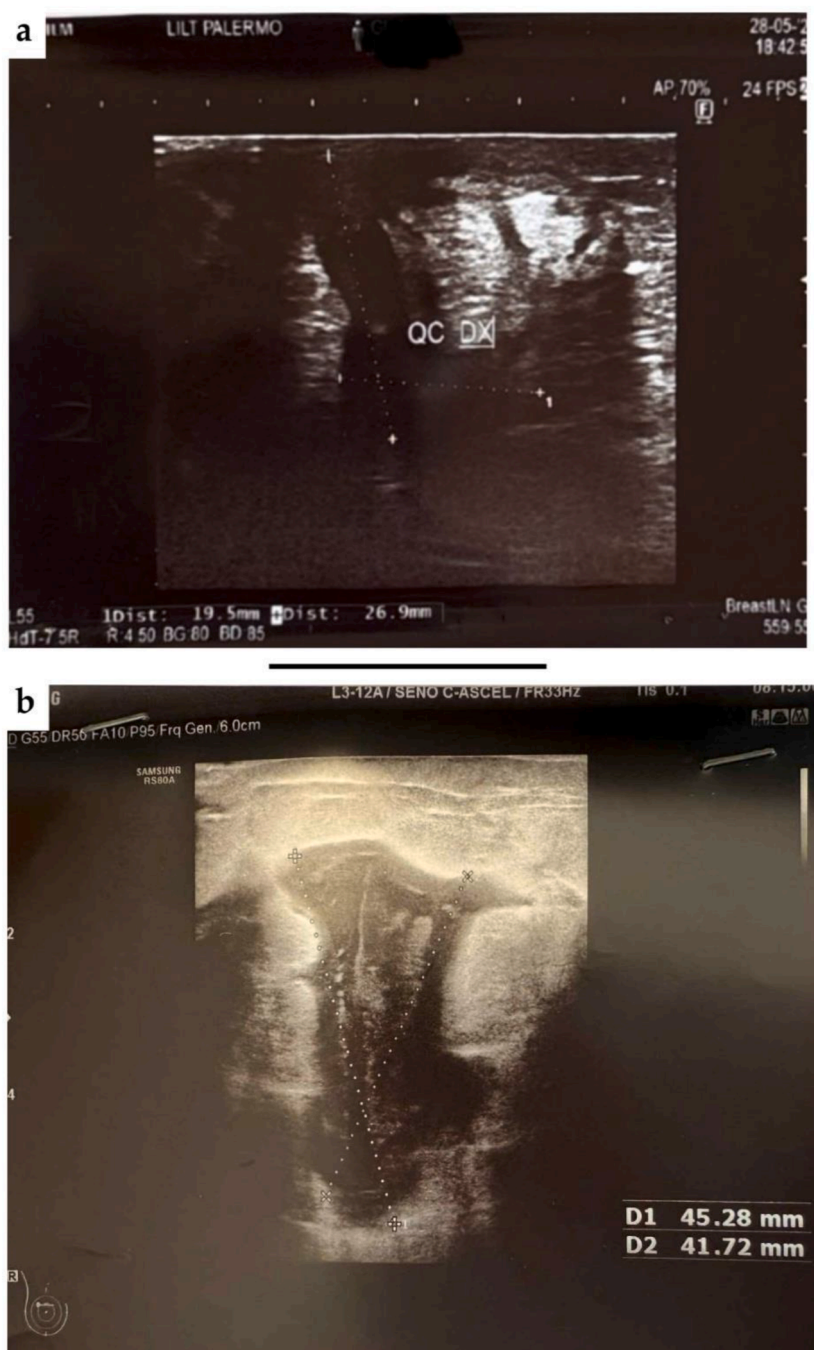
Ultrasonographic evaluation of the right retro-areolar breast region.
